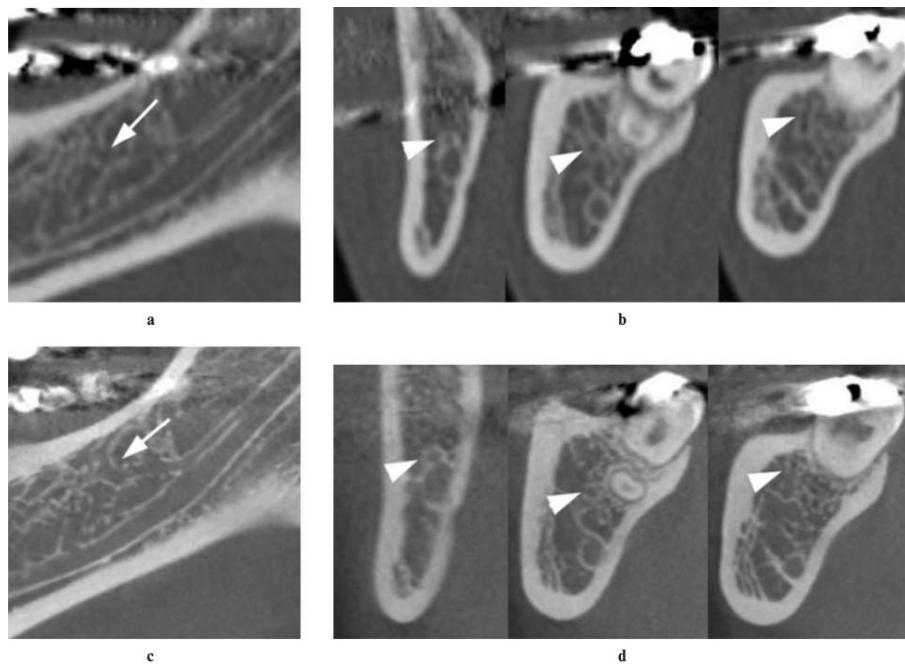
Comparison between MSCT (above) and CBCT (below) images of the same patient. The improved clarity and ability to distinguish trabeculae in cancellous bone from the RMC (arrows) renders CBCT superior to MSCT for the task of detecting RMCs. A) Sagittal section of the RMC using MSCT; B) coronal sections of the RMC using MSCT; C) Sagittal section of the RMC using CBCT; D) coronal sections of the RMC using CBCT. (9)
